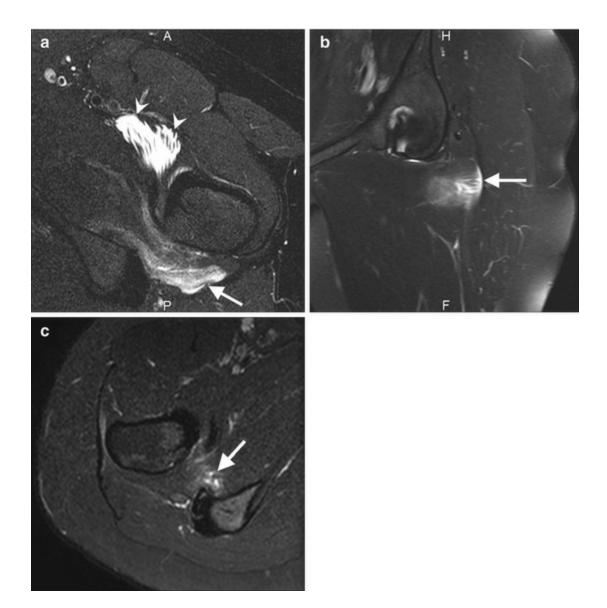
Traumatic injury of the quadratus femoris muscle. A 26-year-old female dancer. (a) Axial and (b) coronal fat-suppressed T2-weighted MRI show a frank partial tear (white arrow). There is also a partial tear of the iliopsoas muscle (white arrowheads on a). (c) A 23-year-old female dancer. Axial fat-suppressed T2-weighted MRI shows a moderate partial tear (white arrow)
